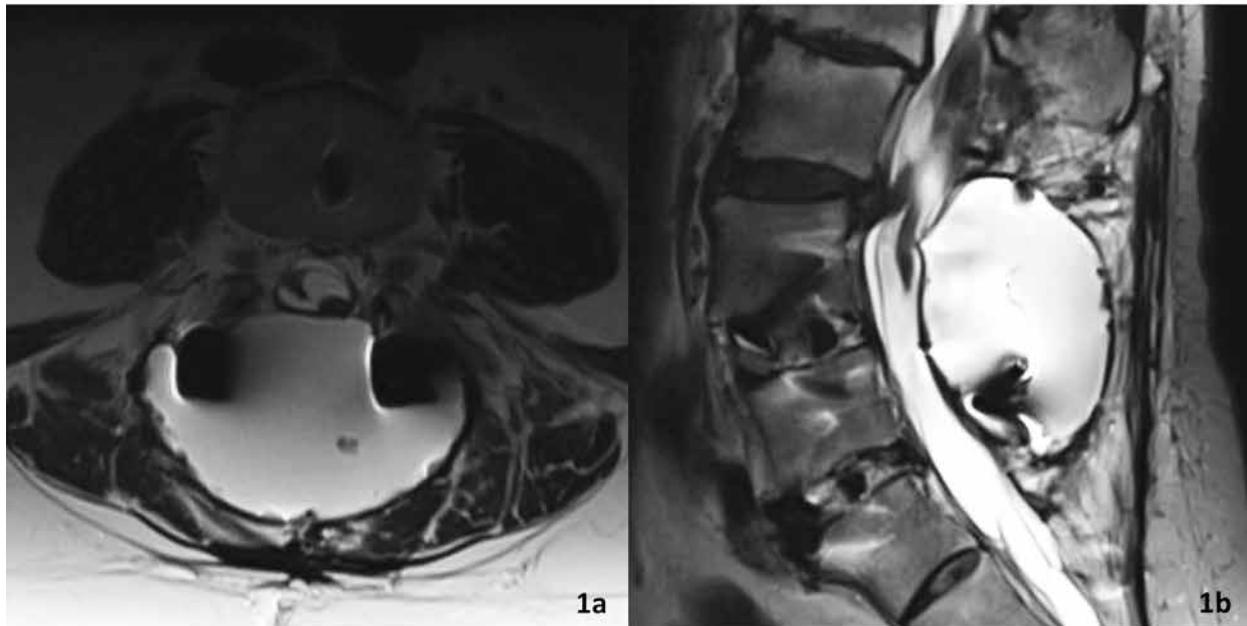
T2 Axial (1a) and Sagittal MRI (1b) demonstrating a fluid collection, isointense on T2-weighted imaging with cerebrospinal fluid, within the surgical bed at the levels of L4-S1. Measurements of fluid collection: 7.1 cm in the transverse dimension, 4.4 cm in the AP dimension, and 6.9 cm in the craniocaudal dimension.
